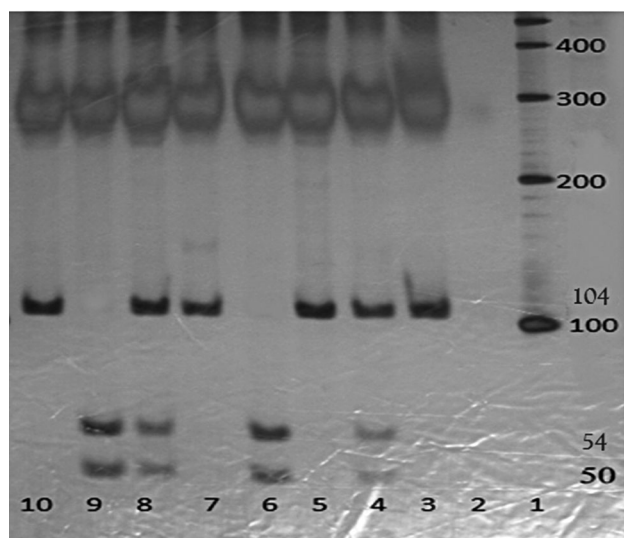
Polyacrylamide gel electrophoresis of PCR products after digestion with *HinfI* restriction enzyme (line 1 is a 100 bp DNA ladder, line 2 is negative control (no DNA), line 3 is positive control (uncut), lines 4 and 8 are heterozygous CT, lines 6 and 9 are homozygous CC, and lines 5, 7, and 10 are homozygous TT, respectively).
